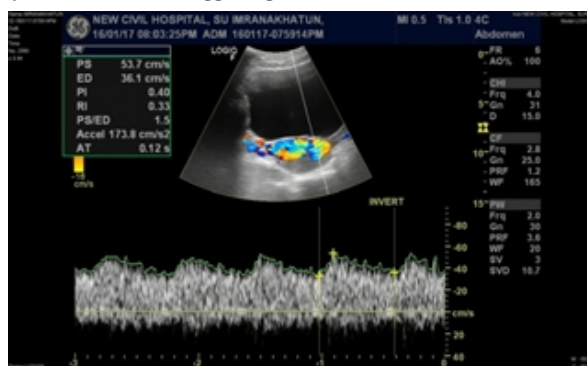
Spectral Doppler US of vascular channels showing pulsatile low resistance high velocity wave form pattern
